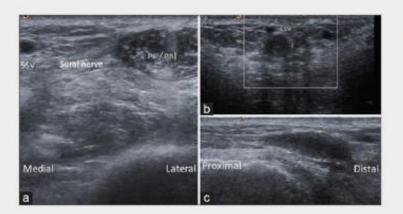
(a) Was obtained by placing the transducer between the peroneus muscle and Achilles tendon where small saphenous vein and sural nerve just there. (b and c) are ultrasound images of the long axis and short axis of part of the sural nerve. SSV: Small saphenous vein, PL: Peroneus longus muscle, PB: Peroneus brevis muscle
